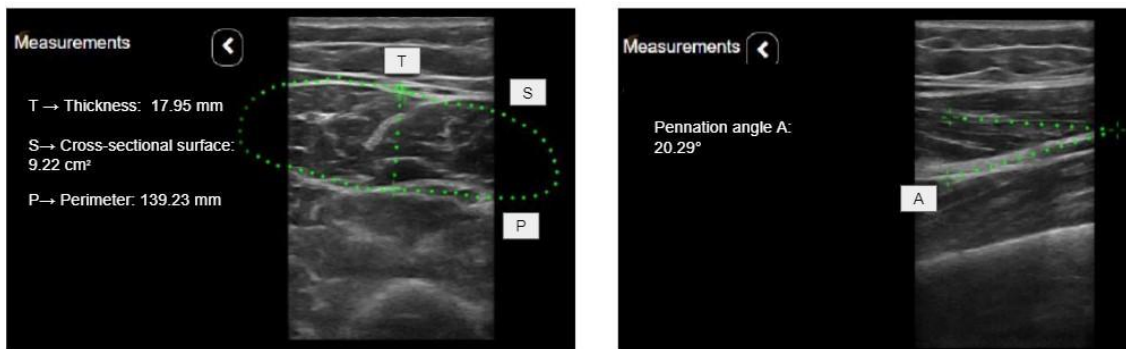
Ultrasound measurements of rectus femoris include (A) thickness, cross-sectional area, and perimeter of the rectus femoris in transverse view, and (B) pennation angle in longitudinal view.
